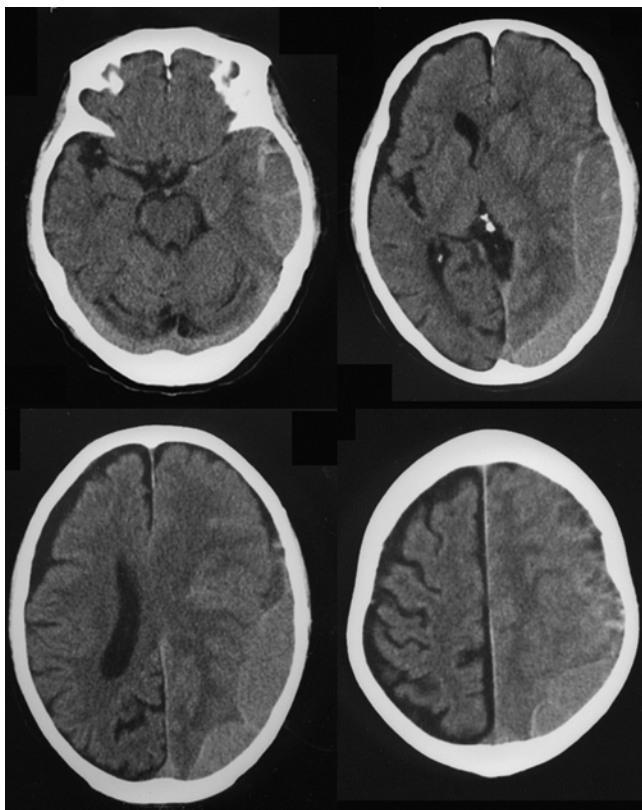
Case 13. CT images on Day 1, at the initiation of tranexamic acid therapy.
